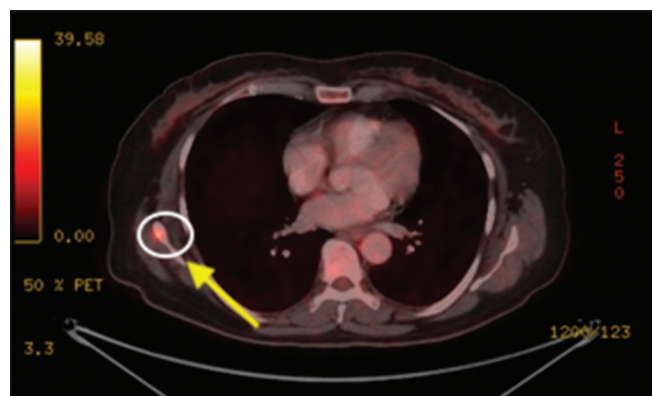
PET CT scan view of a right scapular lesion with 1 cm diameter with significant FDG activity
